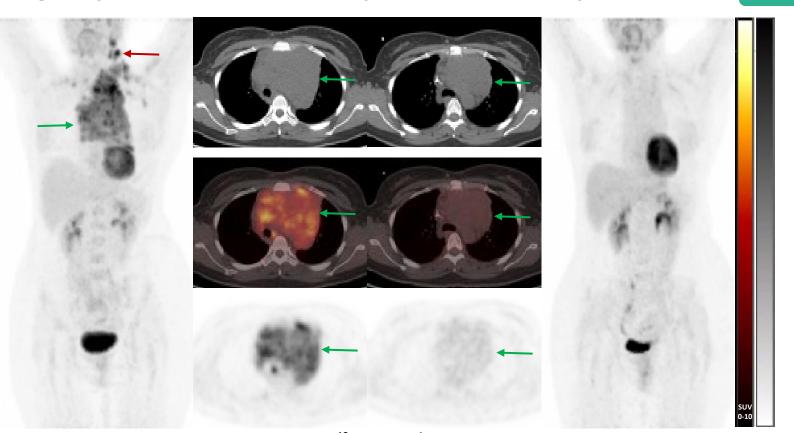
[18F]FDG PET/CT Scan
